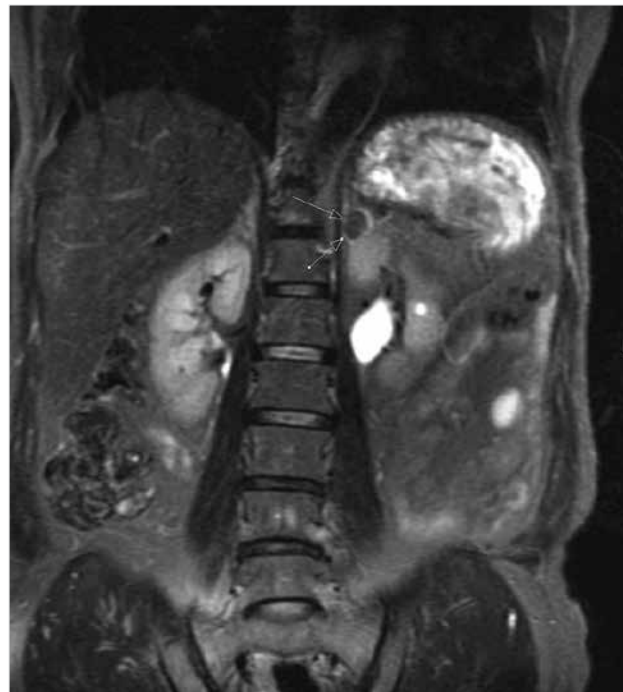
Magnetic resonance imaging examination revealed an adenoma with a diameter of 1.5 cm in the left adrenal gland
